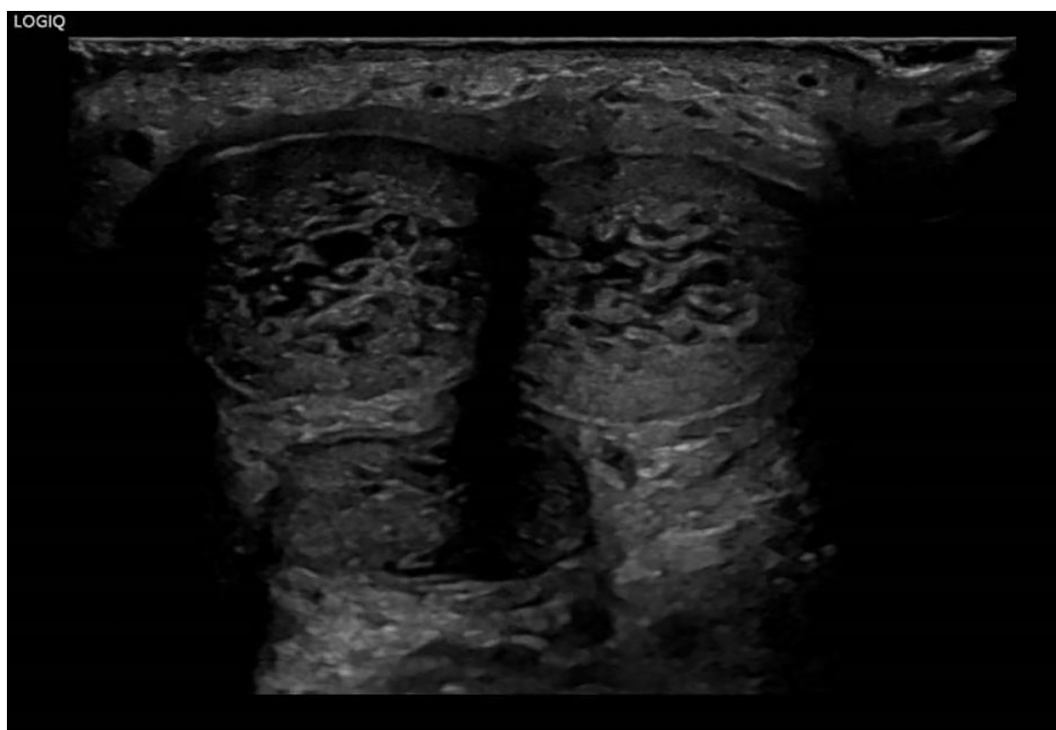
Ultrasound scan of the penis performed around 24 weeks after suprapubic cystostomy showed venous engorgement of the corpora cavernosa and superficial oedema in the penis.
